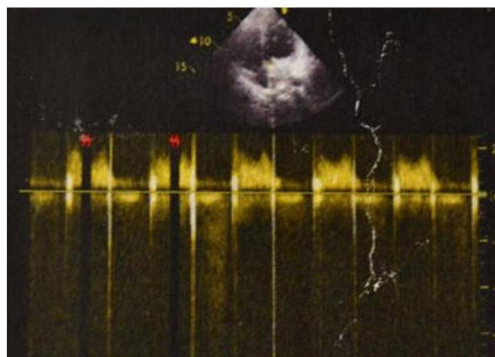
Transthoracic echocardiography demonstrating the echogenicity with thrombus formation on the left ventricular side and on the mechanical mitral valve.
